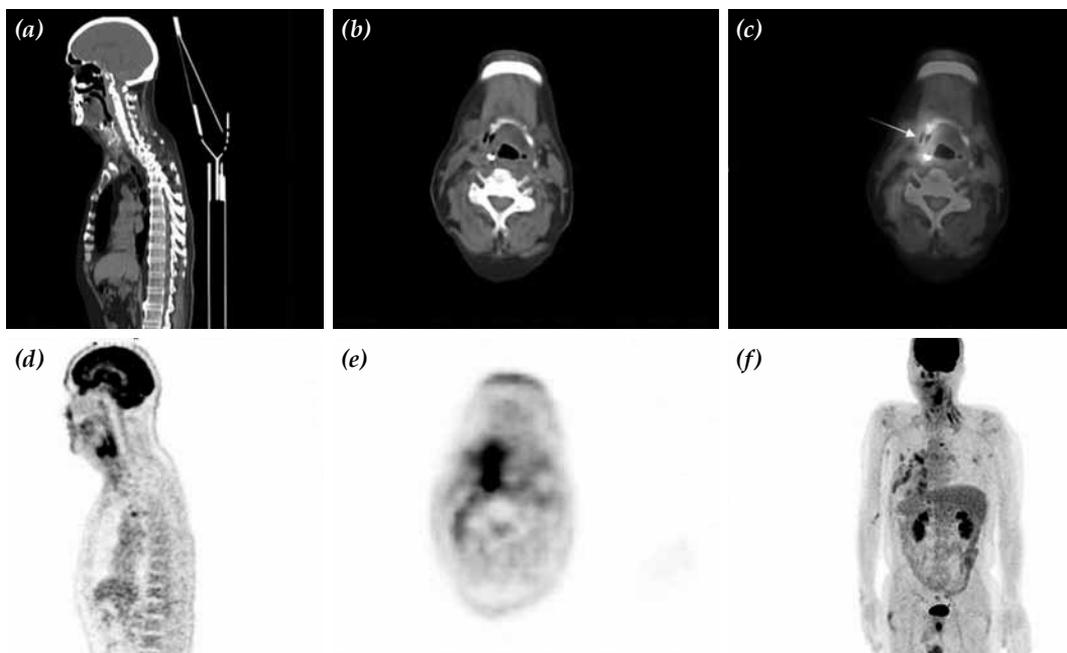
(a) Sagittal, and (b) axial, computed tomography; (c) fused transaxial positron tomography/computed tomography, (d) sagittal, (e) axial and (f) maximum intensity projection positron emission tomography images of the patient. High fluorodeoxyglucose uptake with SUV_{max} value of 12.89 was observed in hyoid bone on transaxial fused positron emission tomography/computed tomography image (arrow).
